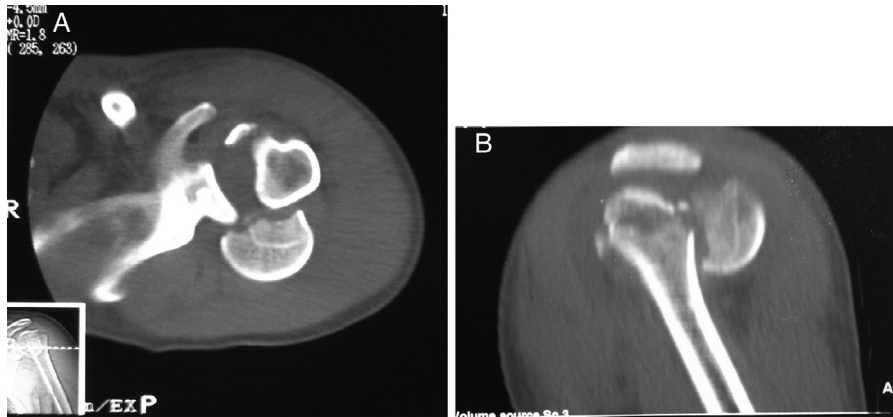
(A) Computed tomography in axial section; (B) computed tomography in sagittal section.
